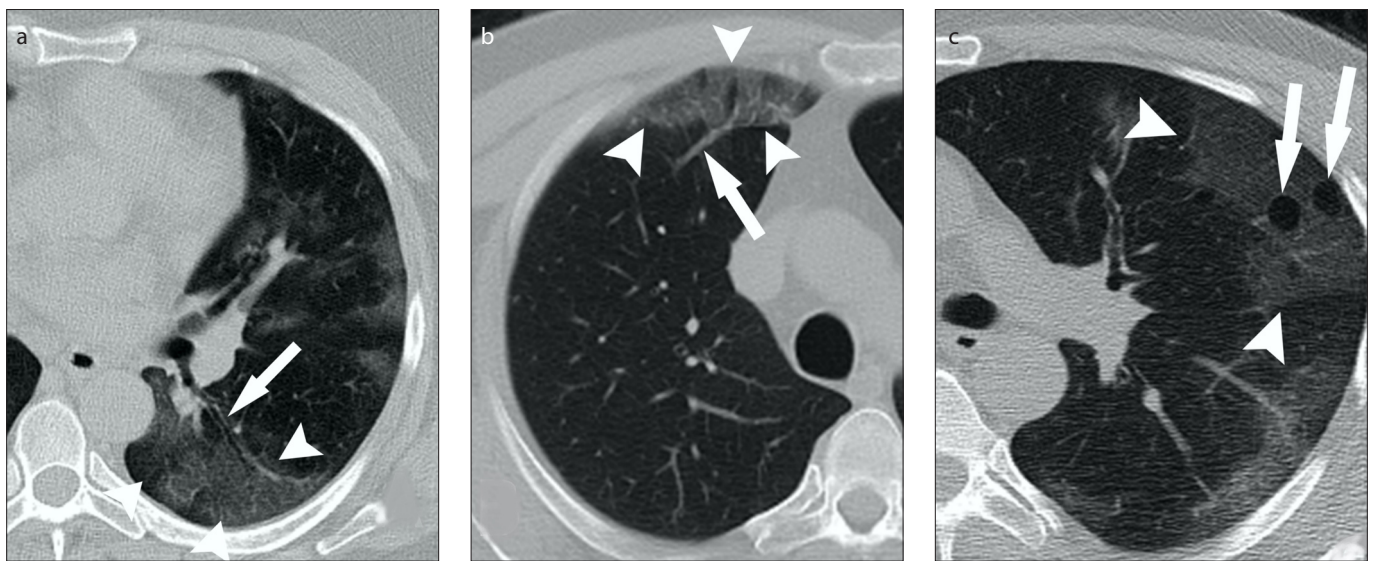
a–c. Axial low-dose chest CT image (a) of a 44-year-old female COVID-19 patient presenting with fever and sore throat for 2 days shows multifocal, peripherally placed patchy GGO in the left lung (*arrowhead*) and enlarged bronchus (*arrow*). Axial low-dose chest CT image (b) of a 55-year-old male COVID-19 patient presenting with headache and myalgia for 3 days shows GGO area (*arrowheads*) in the right middle lobe with vascular enlargement (*arrow*). Axial low-dose chest CT image (c) of a 51-year-old male COVID-19 patient presenting with fever, sore throat, and myalgia shows a peripheral GGO (*arrowheads*) with cystic changes (*arrows*) in the upper left lobe.
